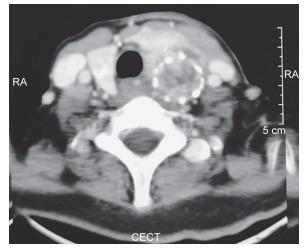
CT scan showing ill-defined planes with strap muscles
